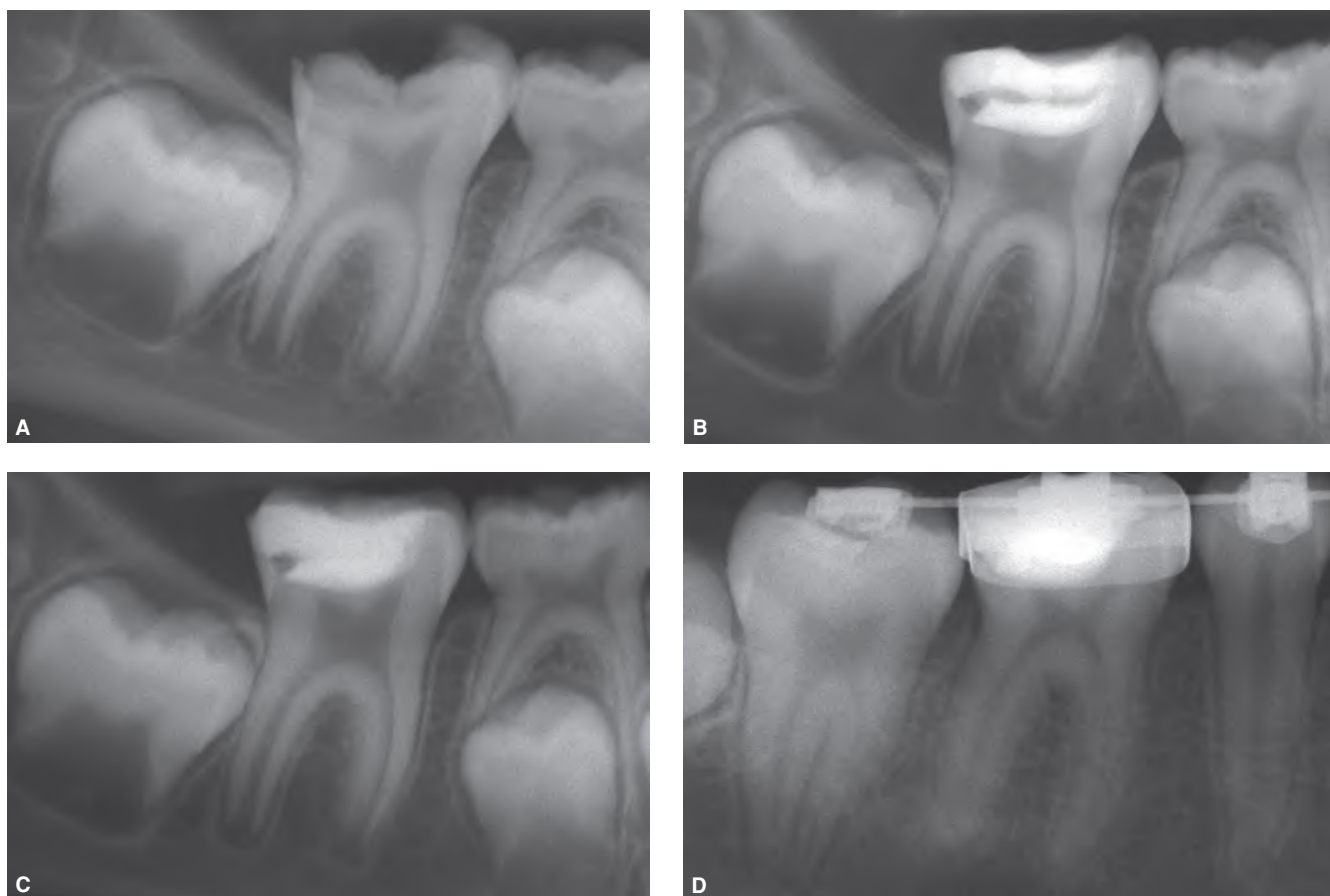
A. Seven-year-old female patient presents with a symptomatic mandibular first molar exhibiting deep caries and open apices. B,C. Patient received direct MTA pulp capping and bonded restoration in a two-visit sequence. D. Radiographic recall at seven years shows mature apices. Orthodontic treatment ongoing. Normal response to cold testing. (Reproduced with permission from Bogen and Chandler.²)
